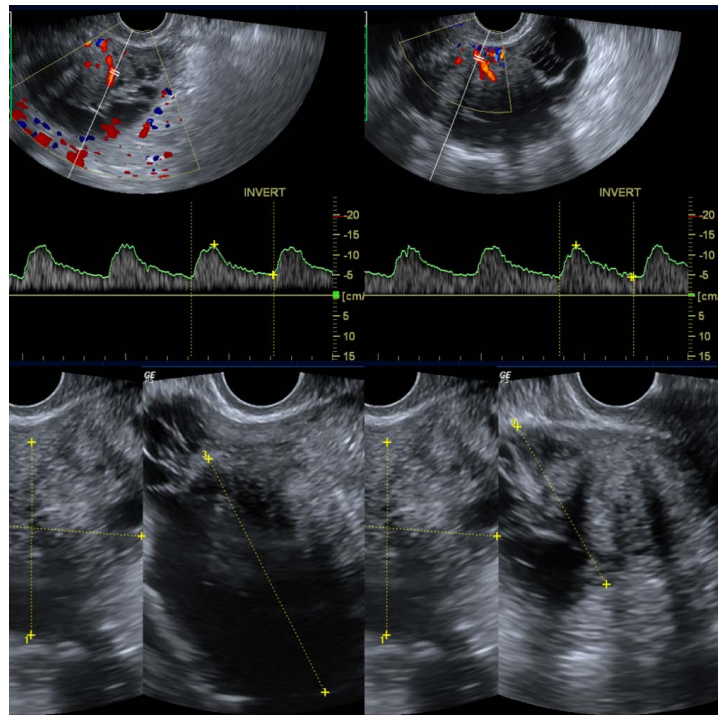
Transvaginal sonography of a malignant featuring right mixed ovarian mass lesion with increased vascularity in color flow mapping.
